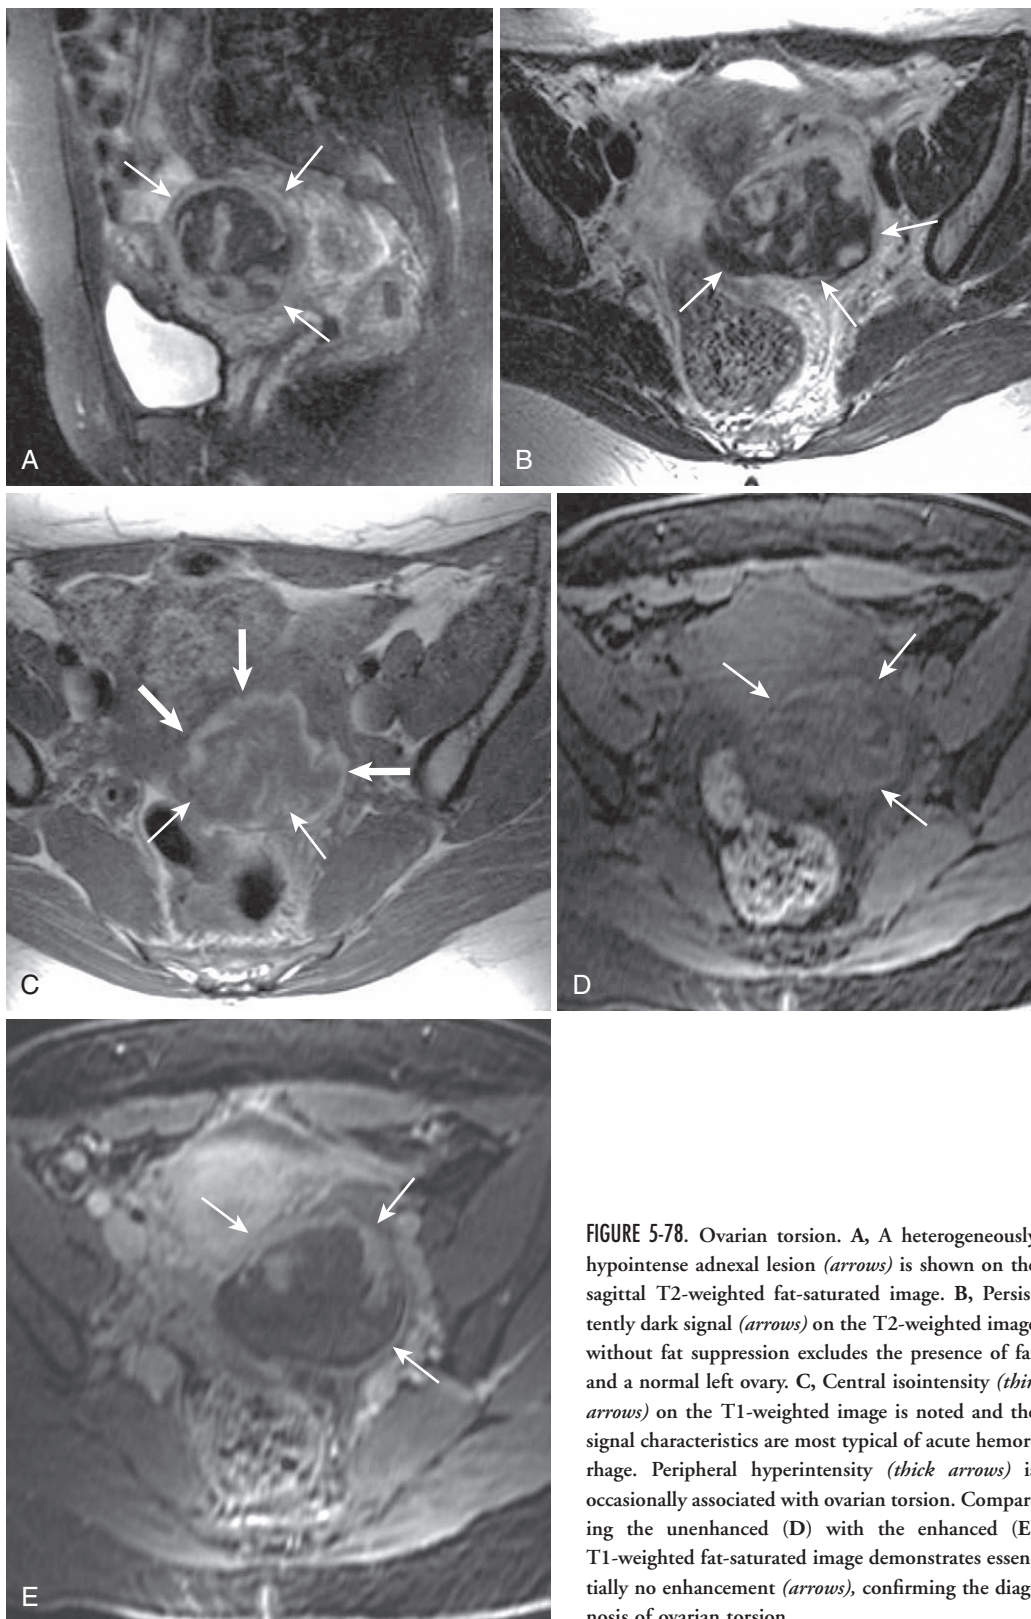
Ovarian torsion. A, A heterogeneously hypointense adnexal lesion (*arrows*) is shown on the sagittal T2-weighted fat-saturated image. B, Persistently dark signal (*arrows*) on the T2-weighted image without fat suppression excludes the presence of fat and a normal left ovary. C, Central isointensity (*thin arrows*) on the T1-weighted image is noted and the signal characteristics are most typical of acute hemorrhage. Peripheral hyperintensity (*thick arrows*) is occasionally associated with ovarian torsion. Comparing the unenhanced (D) with the enhanced (E) T1-weighted fat-saturated image demonstrates essentially no enhancement (*arrows*), confirming the diagnosis of ovarian torsion.
